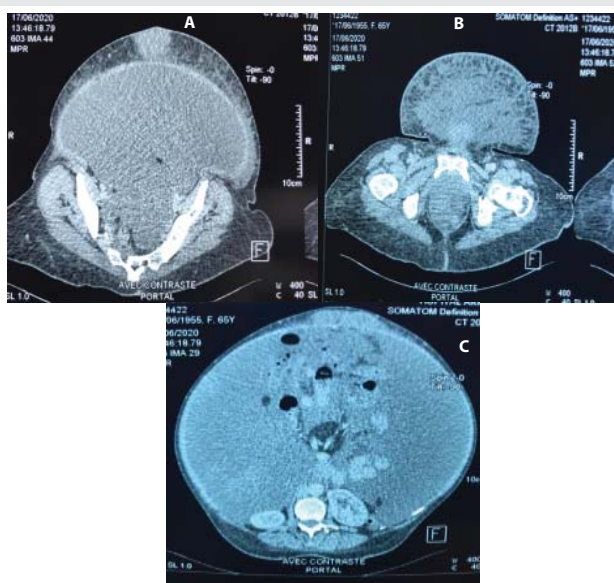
(A,B,C): CT scans revealing dense peritoneal effusion occupying all compartments of the abdomen and the pelvic floor, responsible for scalloping of the hepatic and splenic parenchyma and repression of the intestinal loops.
